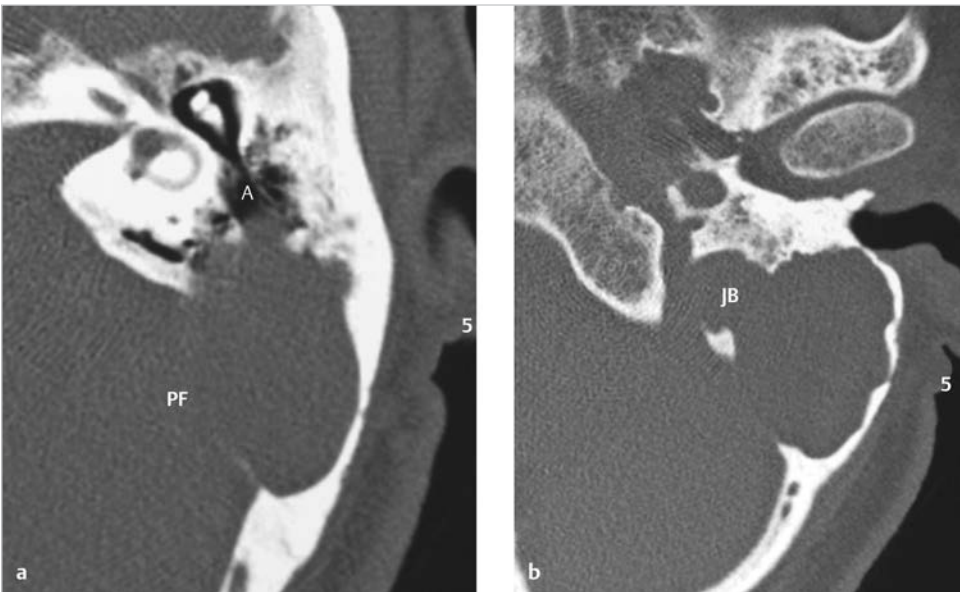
A case of congenital cholesteatoma in the mastoid is shown. The axial CT at the level of the lateral semicircular canal (a) shows presence of soft tissue in the mastoid with expansive growth eroding and pushing the posterior fossa. The mass partially infiltrates the antrum, but no pathology is found in the attic. The caudal slice (b) shows large bony erosion in the jugular bulb. A, antrum; JB, jugular bulb; PF, posterior fossa.
